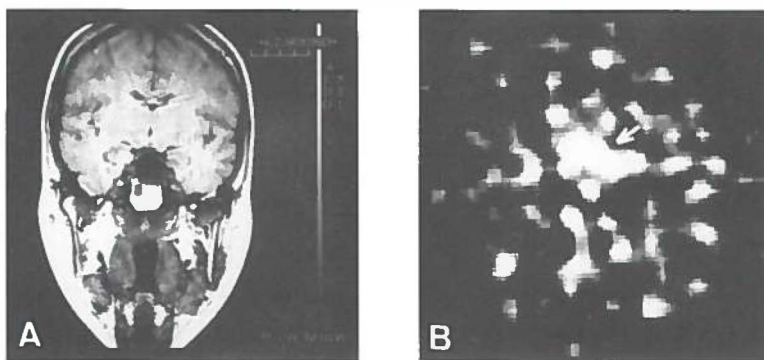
(A) MRI study of prolactinoma (patient 7) in a coronal slice. The prolactinoma tissue shows a clear signal heterogeneity. (B) L -[methyl- ^{11}C]methionine PET study in a transaxial slice, position of the with the arrow, on the ^{11}C -tyr PET image (C). In each of the four ^{18}F FDG tumor is indicated with an arrow.
